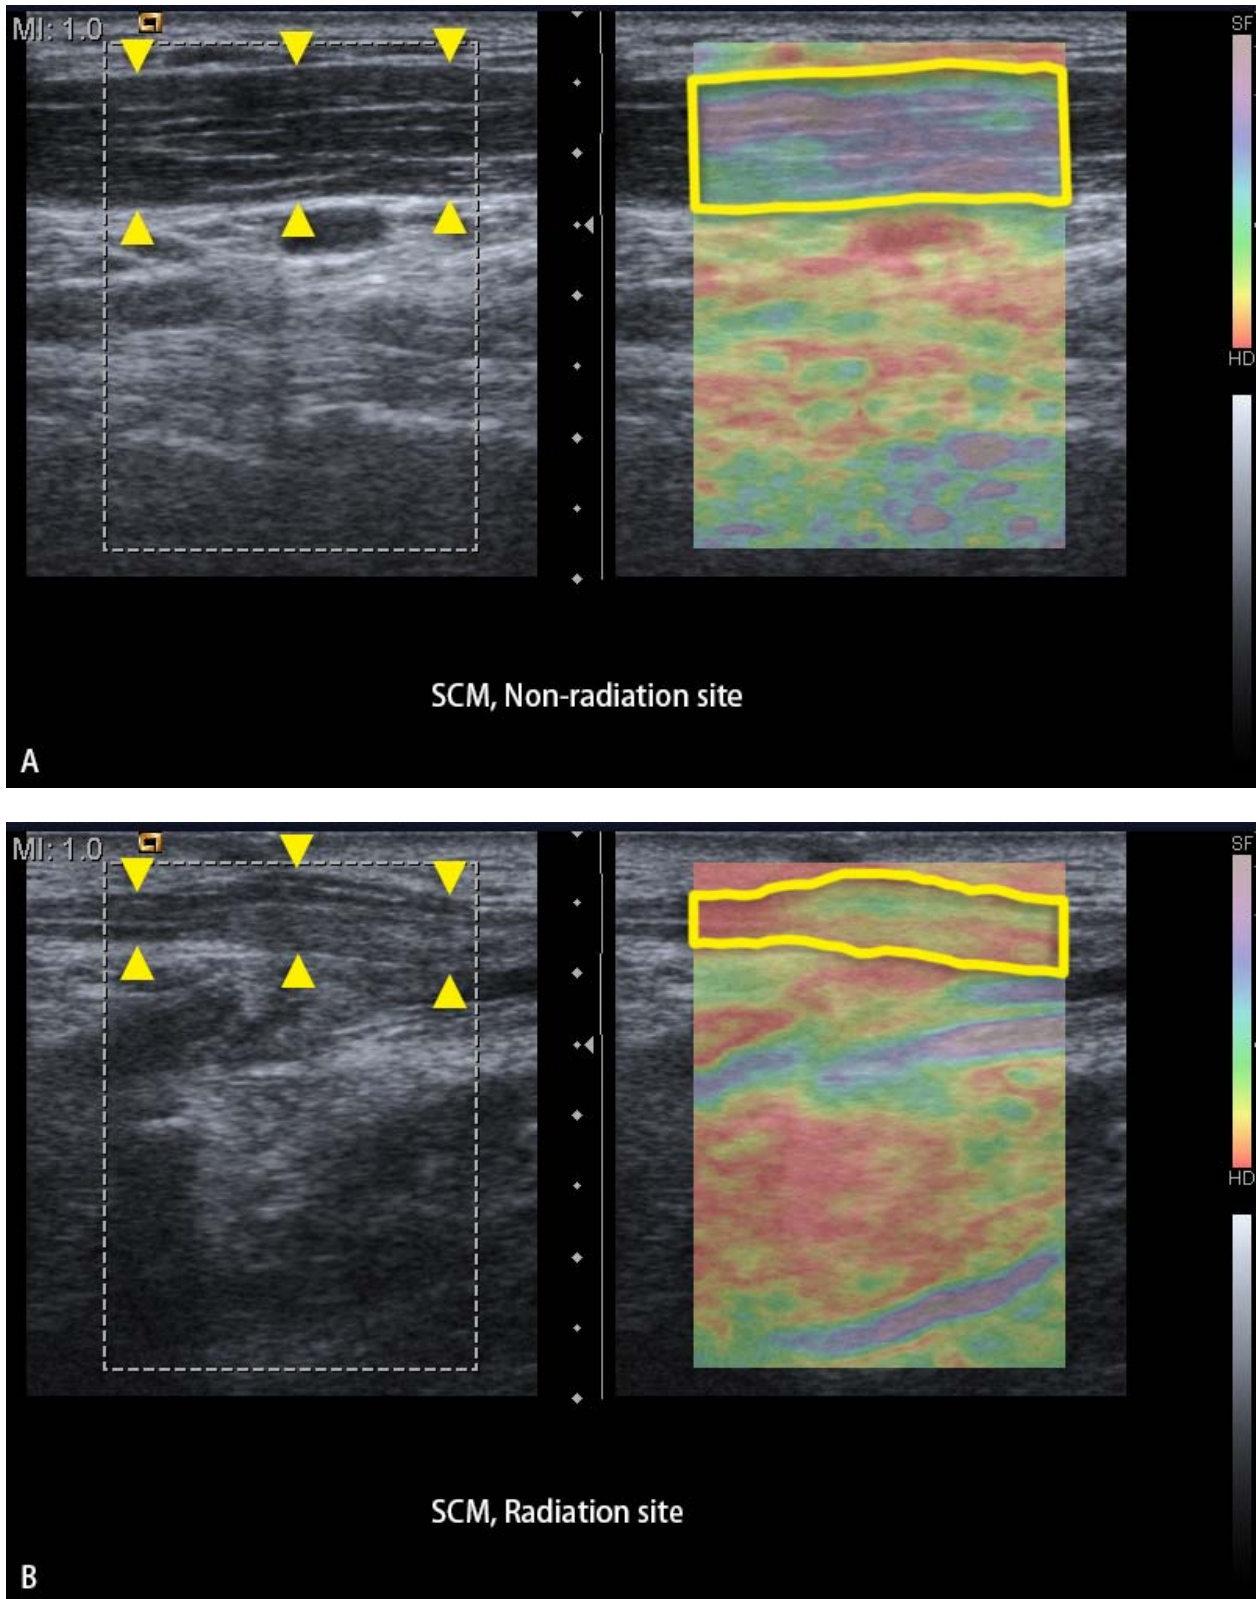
Real-time sonoelastography. (A) non-radiation site, (B) radiation site. The yellow arrow heads of B-mode sonogram (left side panel) mark the area of SCM, the yellow frame of color-coded sonogram (right side panel) mark the range for calculating the red and yellow area.
